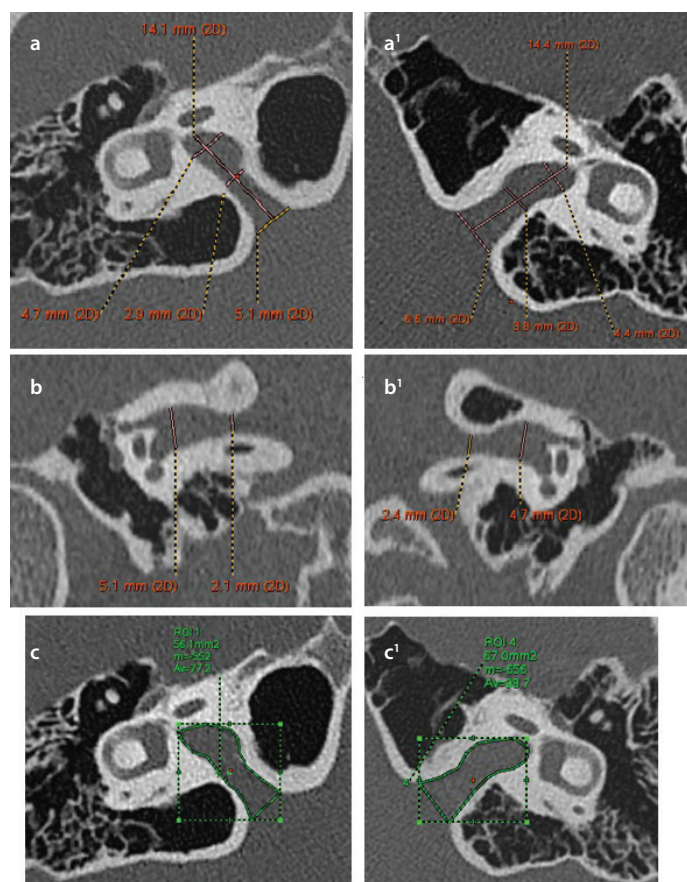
a-c. Temporal bone high-resolution computed tomography (HRCT) in axial plane showing hyperpneumatization of the petrous bone at the level of IAC. a) and a') (right- and left-hand sides): hyperpneumatized IAC walls; prolonged IAC length of 14.1 mm on the right-hand side and 14.4 mm on the left-hand side. b) and b') (right- and left-hand sides): HRCT coronal plane. Bilateral IAC stenosis. Significantly reduced porus IAC height: 2.1 mm on the right-hand side and 2.4 mm on the left-hand side. c) and c') (right- and left-hand sides): HRCT axial plane. IAC areas normal or slightly increased.
